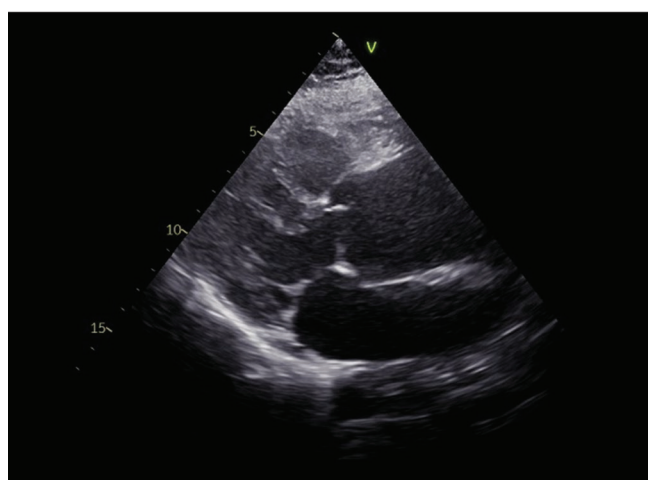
Echocardiographic image of the dilated aortic root and ascending aorta (yellow arrow).
